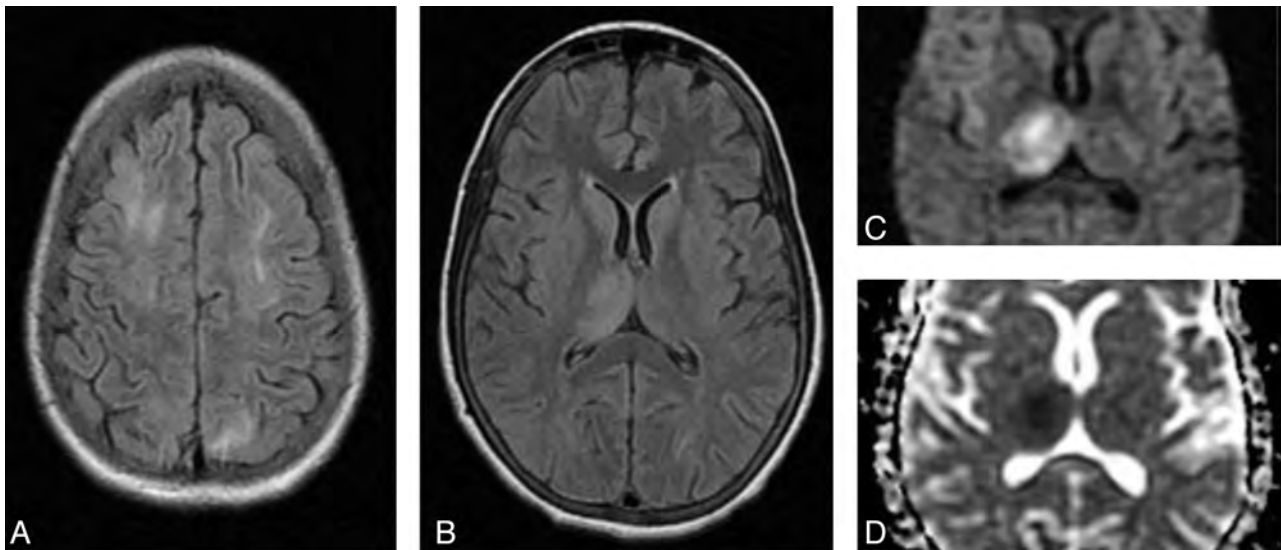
Brain MR images of a 20-year-old woman with early postpartum eclampsia. A, FLAIR MR image shows edema involving the bilateral frontal and parietal regions. FLAIR (B), DWI (C), and ADC (D) show involvement of the right thalamus with cytotoxic edema.
